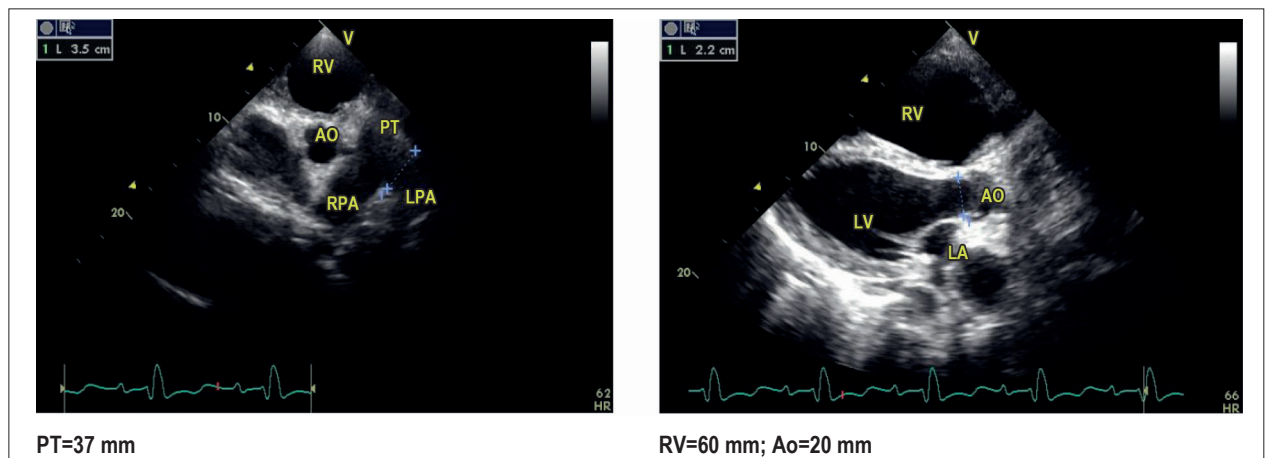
Transthoracic echocardiogram. Left: parasternal view in the short axis: dilation of pulmonary trunk (PT) and right and left branches of the pulmonary artery (RPA and LPA). Right: parasternal view in the long axis: right ventricle (RV) dilation and interventricular septal rectification.
